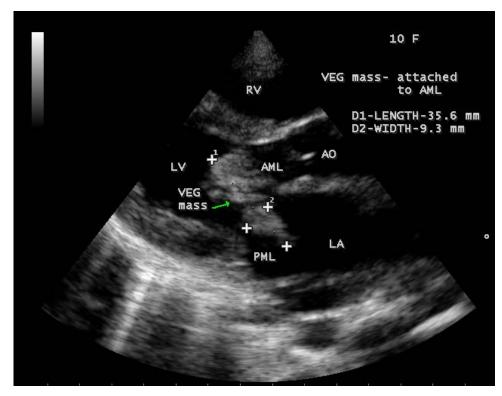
Vegetation embedded on AML in parasternal long axis view ([33], Figure 13.7A).
